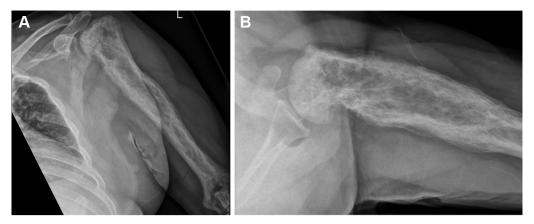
Preoperative AP (A) and axillary (B) radiographs demonstrating Paget's disease involving the entirety of the left humerus as well as humeral head deformity and proximal migration.
